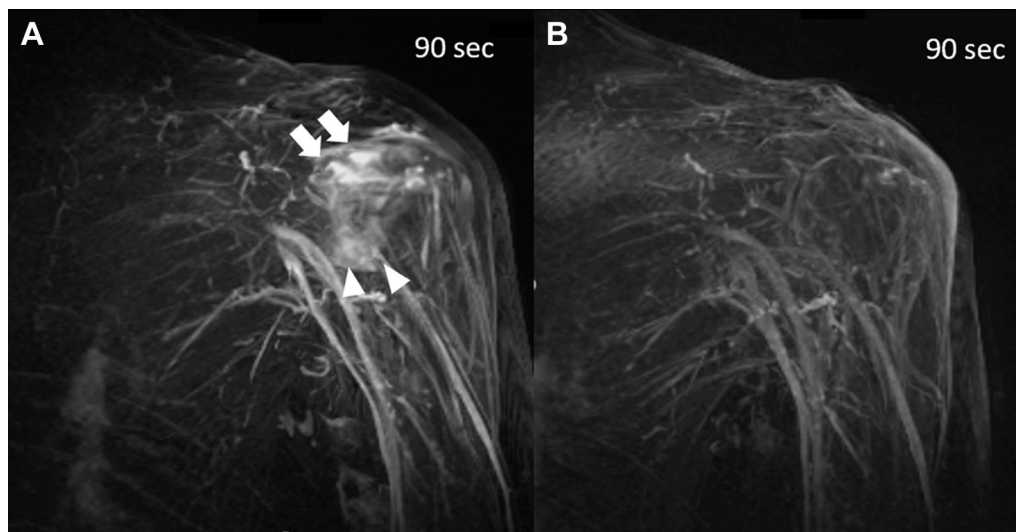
A 54-year-old female patient with idiopathic frozen shoulder of the Left side. (A) Dynamic 3D MRI shows abnormal enhancement (burning sign) at the AP (arrow head) and RI (arrow) before MUC. (B) Dynamic 3D MRI shows the same patient six months after MUC. The burning sign disappeared. Both images are at 90 seconds after the gadolinium intravenous injection (Middle phase). 3D, 3-dimensional; MRI, magnetic resonance imaging; MUC, manipulation under ultrasound-guided cervical nerve root block; AP, axillary pouch; RI, rotator interval.
